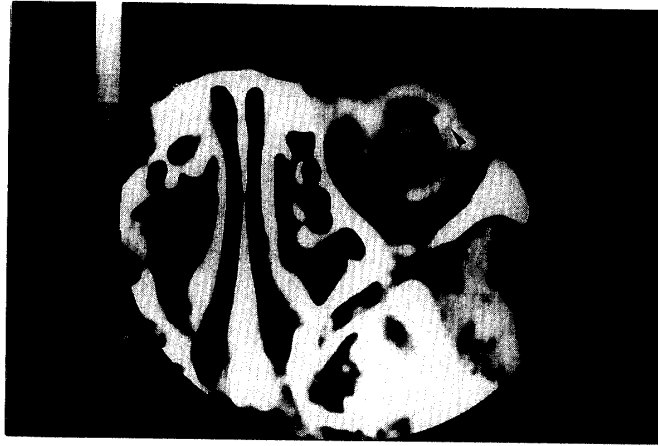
Preoperatively, a computed tomographic scan of the orbit demonstrates the intraocular presence of a high-density mass (arrow).
